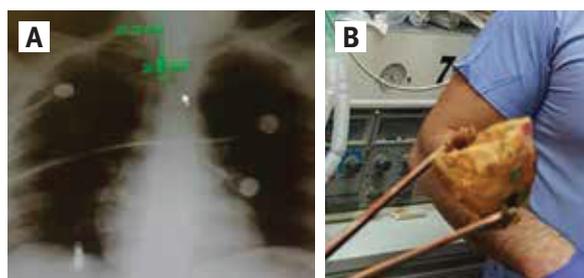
[A] Portable chest X-ray showing large opacity in the lower neck consistent with an ingested foreign body [B] The large stone recovered from the esophageal inlet of the patient
